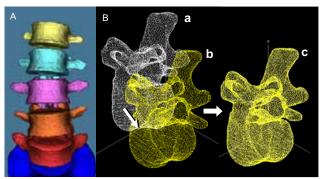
(A) 3D reconstruction of subject's lumbar spine from CT scans. (B)Vertebral body in the neutral position (a) was virtually rotated and translated toward the real rotated position (b) with 0.1° and 0.1mm increments, respectively, until the highest value of volume merge was calculated (c).
